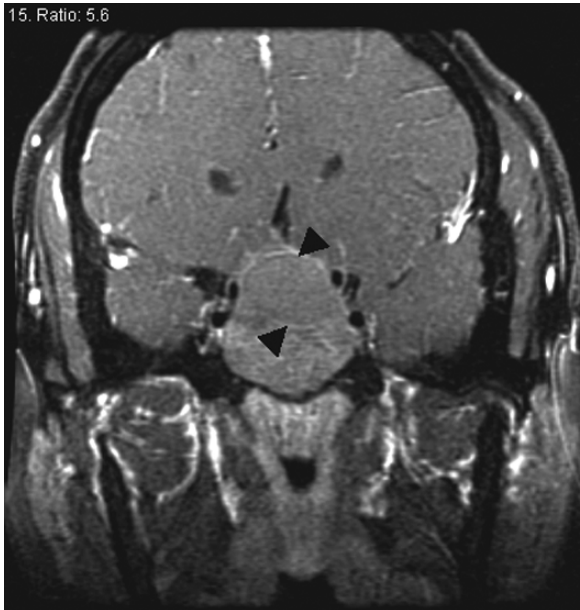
Magnetic resonance imaging of a coronal section through a pituitary macroadenoma with hemorrhage (arrows)
